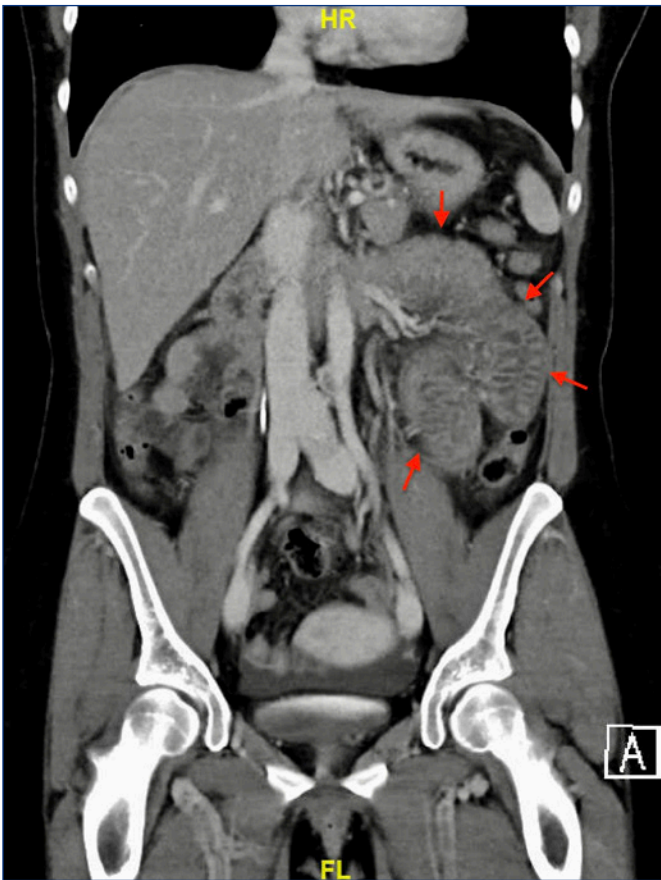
Coronal view of computed tomography of the abdomen and pelvis with contrast demonstrating loops of dilated, thickened small bowel (labeled with red arrows) as well as a small amount of free fluid in the paracolic gutters and pelvis.
